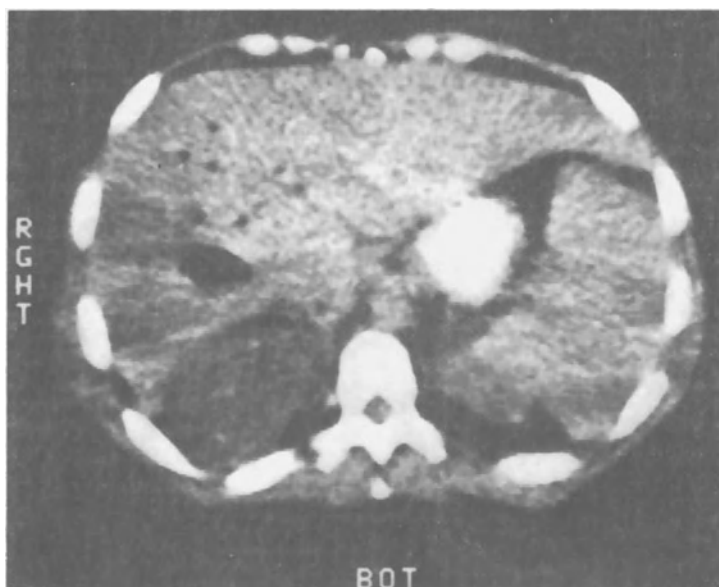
Computed tomography: Liver scan with cystic dilation of the biliary tree in the right lobe. The stomach contains contrast material. Diagnosis of Caroli's disease confirmed by operation. (Heger.)
